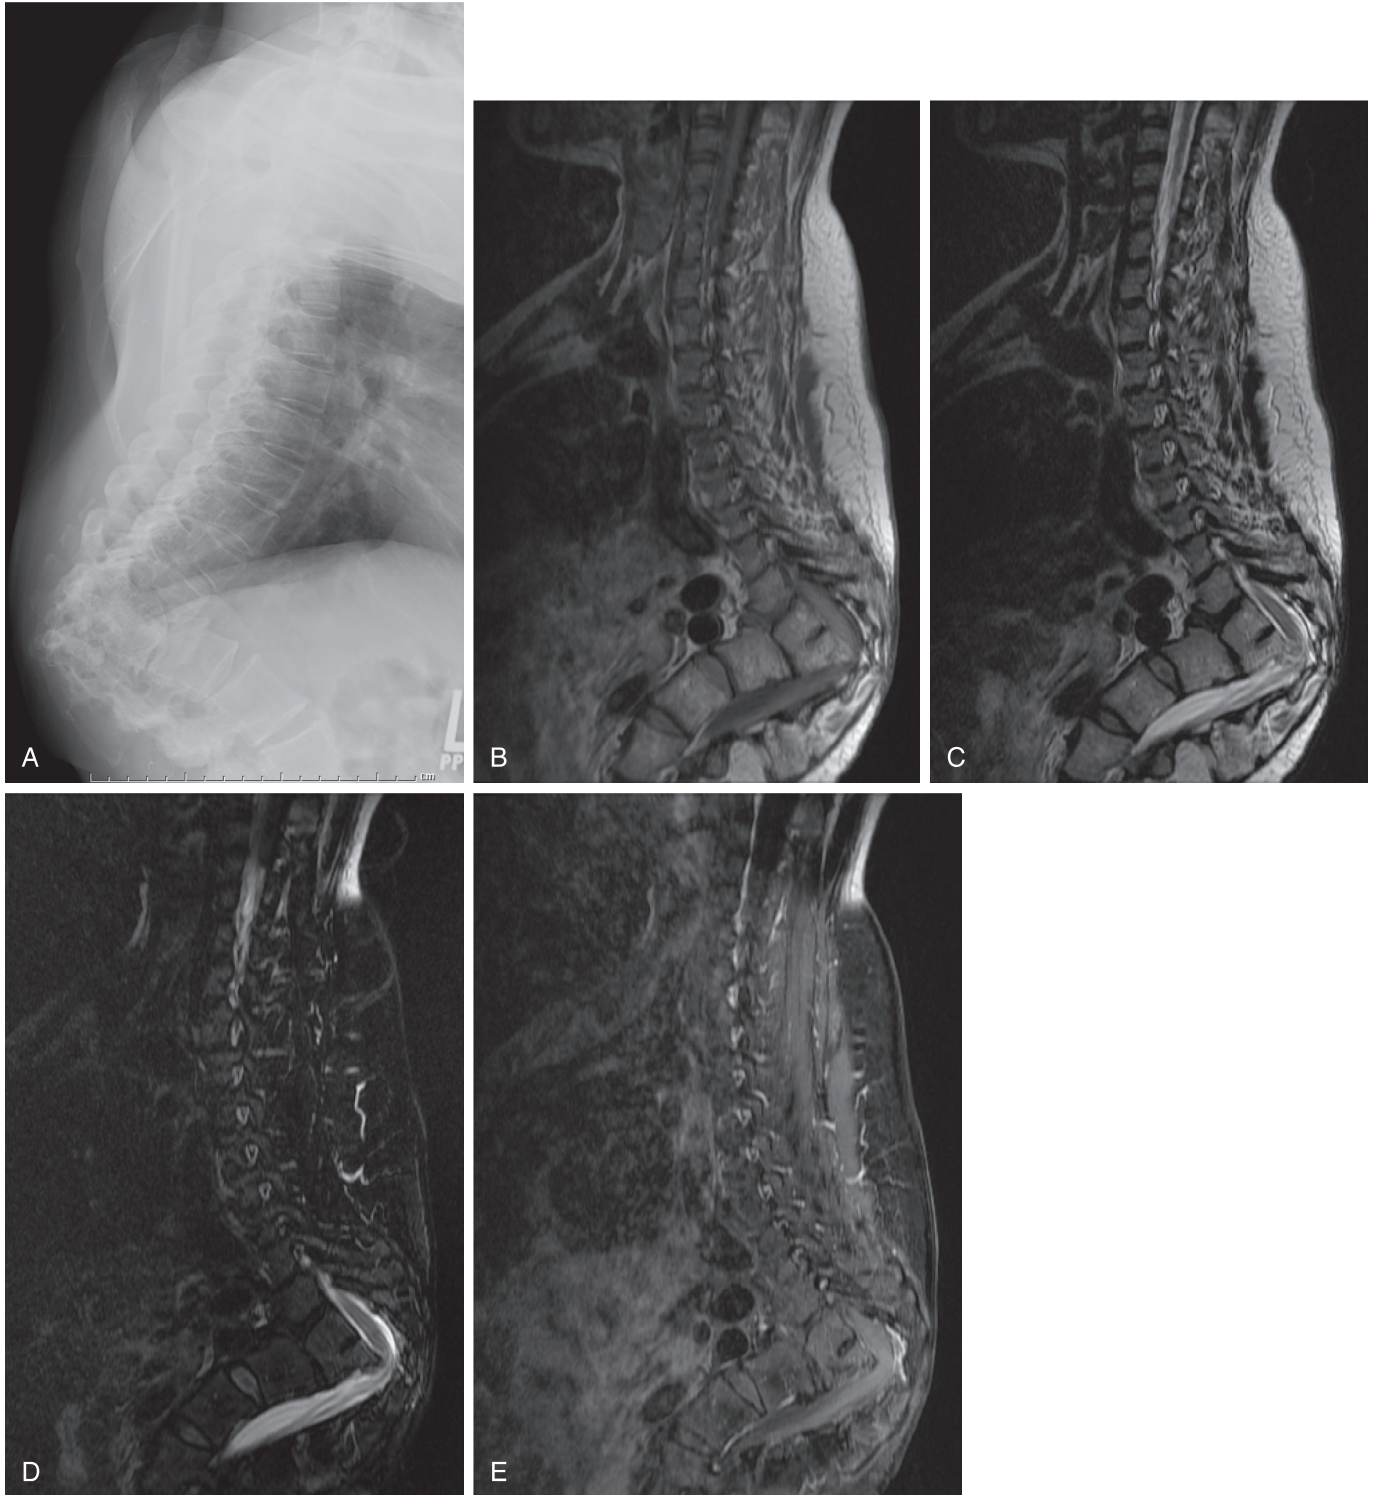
Gibbus deformity of spinal tuberculosis. Lateral radiograph of the spine (A) demonstrates severe focal kyphosis of the upper lumbar spine. Sagittal T1 (B), T2 (C), STIR (D), and postcontrast T1 (E) images of the thoracolumbar spine demonstrate severe focal kyphosis with vertebral collapse. No bone marrow edema or paraspinal abscess is identified, which is consistent with remote chronic disease changes.
